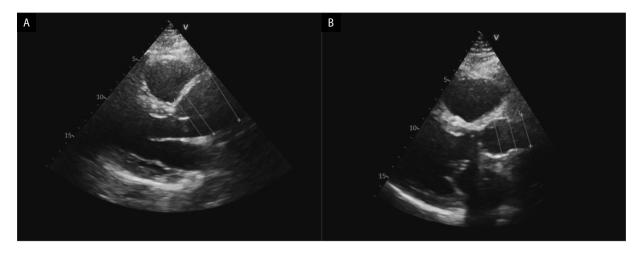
A. Dilation of ascending aorta in echocardiography. 1 — aortic root diameter (4.7 cm), 2 — sinotubular junction diameter (5.2 cm), 3 — (5.5cm). B. Post Bentall de Bono operation status. Artificial aortic valve St Jude Medical (SJM) ascending aorta diameter Masters 25 VAVGJ and ascending aorta vascular prosthesis in echocardiography. 1 — aortic root prosthesis diameter (3.5 cm), 2 — sinotubular junction prosthesis diameter (2.9 cm), 3 — ascending aorta prosthesis diameter (2.9 cm)
